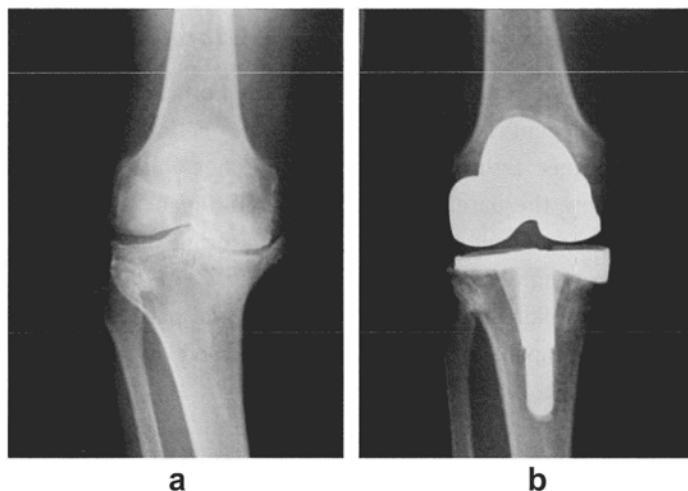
Wedge Third 22° implant for defective portion for TKA. a) Preoperative radiograph, b) Immediately postoperative radiograph
